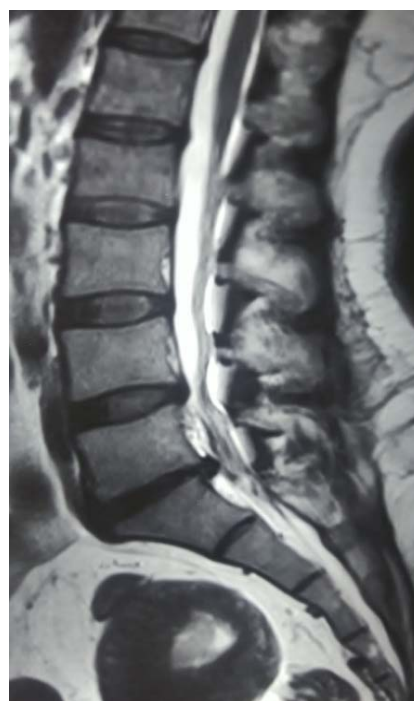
Repeat MRI lumbosacral spine sagittal section showing regression of previously extruded disc at L5-S1 level
